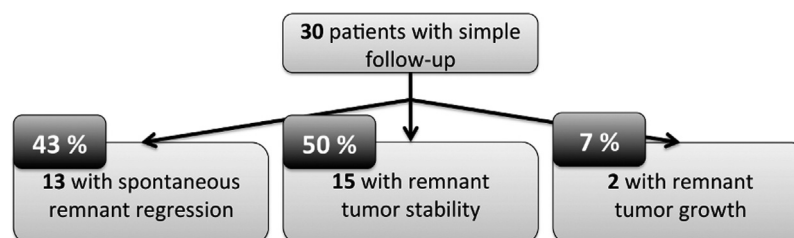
Description of the population of VS non NF2 patients with a per-operative VSTR described by the surgeon. First check-up MRI-scan three months after surgery.
